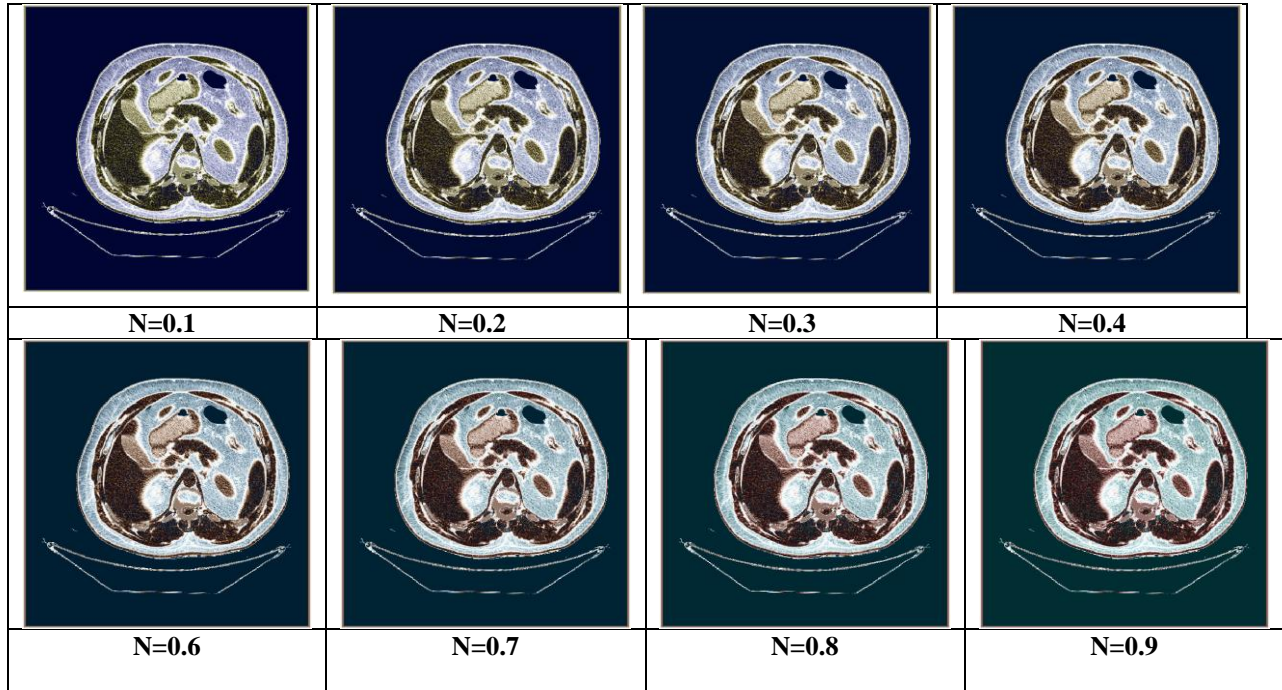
The color output CT-Scan images with different N values
